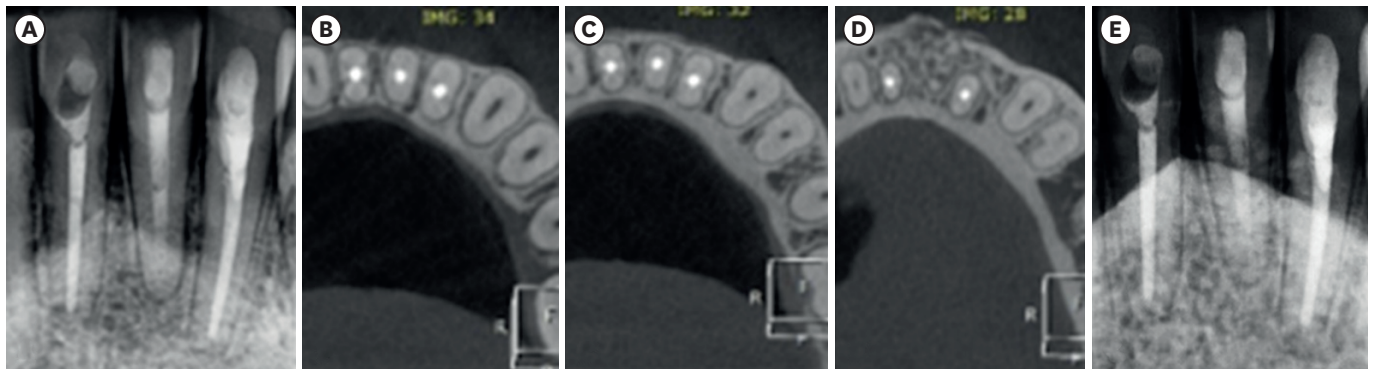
Images referring to the second follow-up (A-D), and 1 month after the surgical procedure (E). (A) 12-month follow-up radiograph indicating complete apical repair. (B-D) Cone-beam computed tomography images (axial views), (B) cervical, (C) middle, and (D) apical sections with evidence of complete apical repair and total remission of the lesion. (E) Periapical radiograph 1 month following apical surgery.
